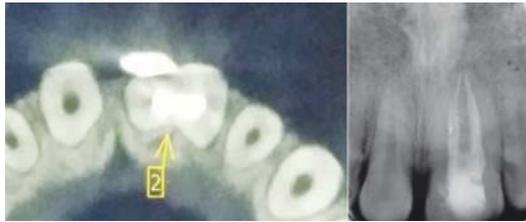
CBCT and postoperative IOIPA image
